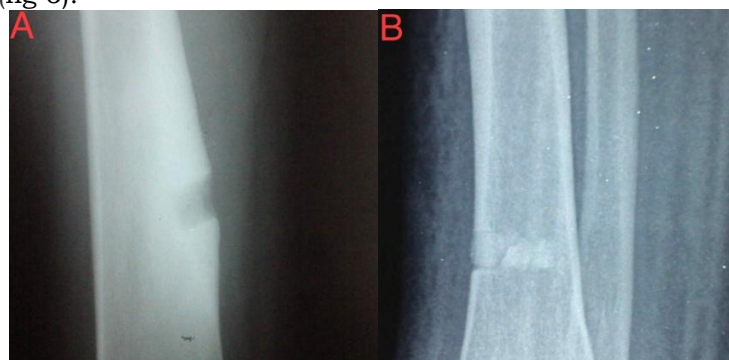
(A) X-Ray lateral view of left femur (Intra-OP post excision). (B) AP view distal tibia showed satisfactory graft in situ
